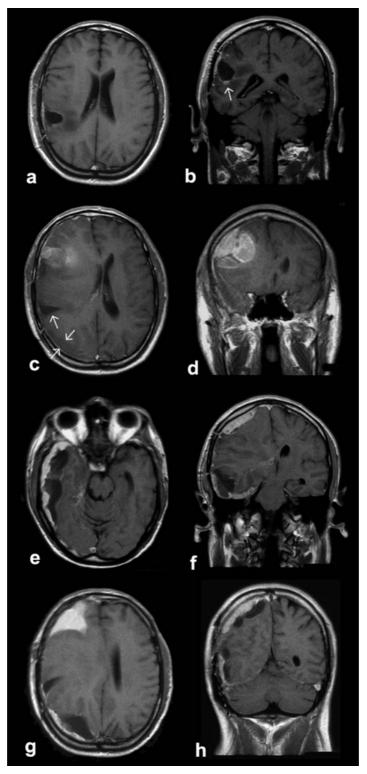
A 35-year-old male patient (Table II, pat. no. 14) underwent complete resection of a right temporal glioblastoma. Nine weeks after surgery, an MRI scan showed a small nodular structure adjacent to the wall of the resection cavity, which was interpreted as a residual/recurrent tumor (a+b). Thirty-one weeks after surgery, the patient complained about a rapid onset of progressive headache. A large right frontal recurrent tumor was found, which appeared to be extracerebral, originating from the meninges. No local progression had occurred at the site of resection (↑). A parieto-occipital subdural fluid collection (→) was observed (c+d). At reoperation the recurrent tumor was completely removed. However, after 5 weeks the patient again presented with similar symptoms. A MRI scan now revealed a more extensive recurrent tumor within the subdural space, a very unusual growth pattern for recurrent glioblastomas (e-h).
